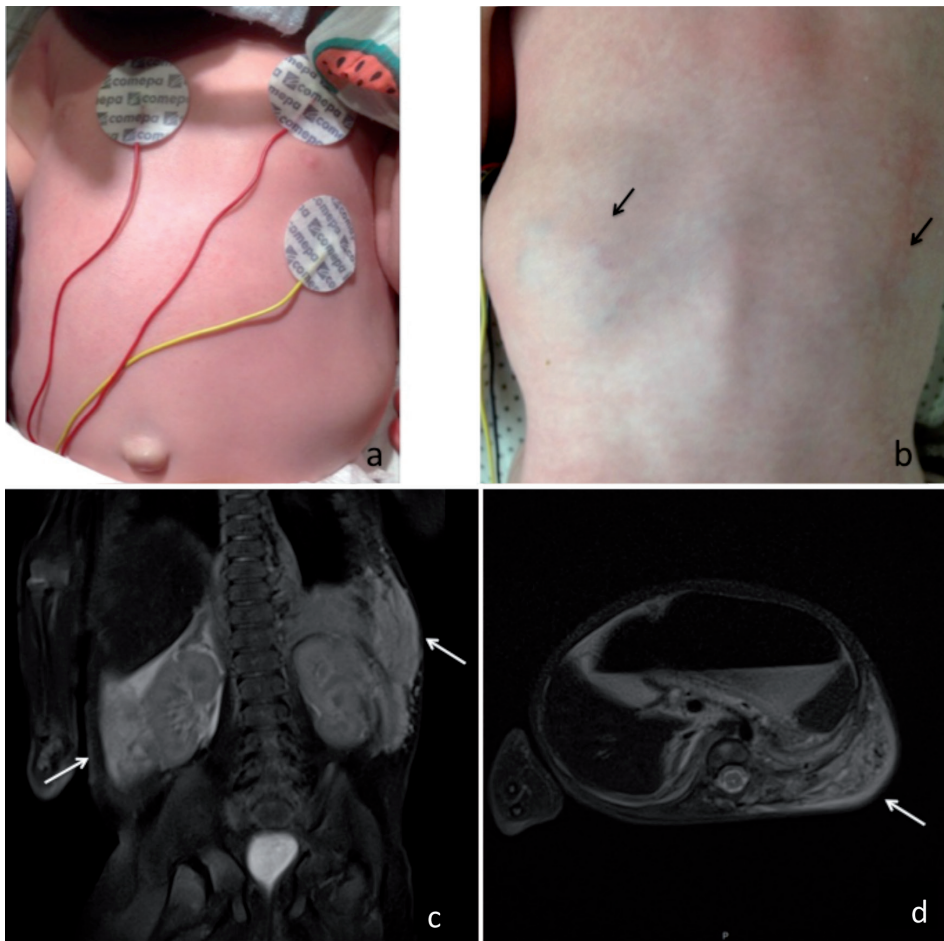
Subcutaneous tufted angioma. (a) Abdominal mass. (b) Tufted angioma appearing as red-blue patches on the infant's back (arrows). (c, d) Abdominal magnetic resonance imaging (MRI), showing subcutaneous tufted angioma of the abdominal wall (white arrows).
